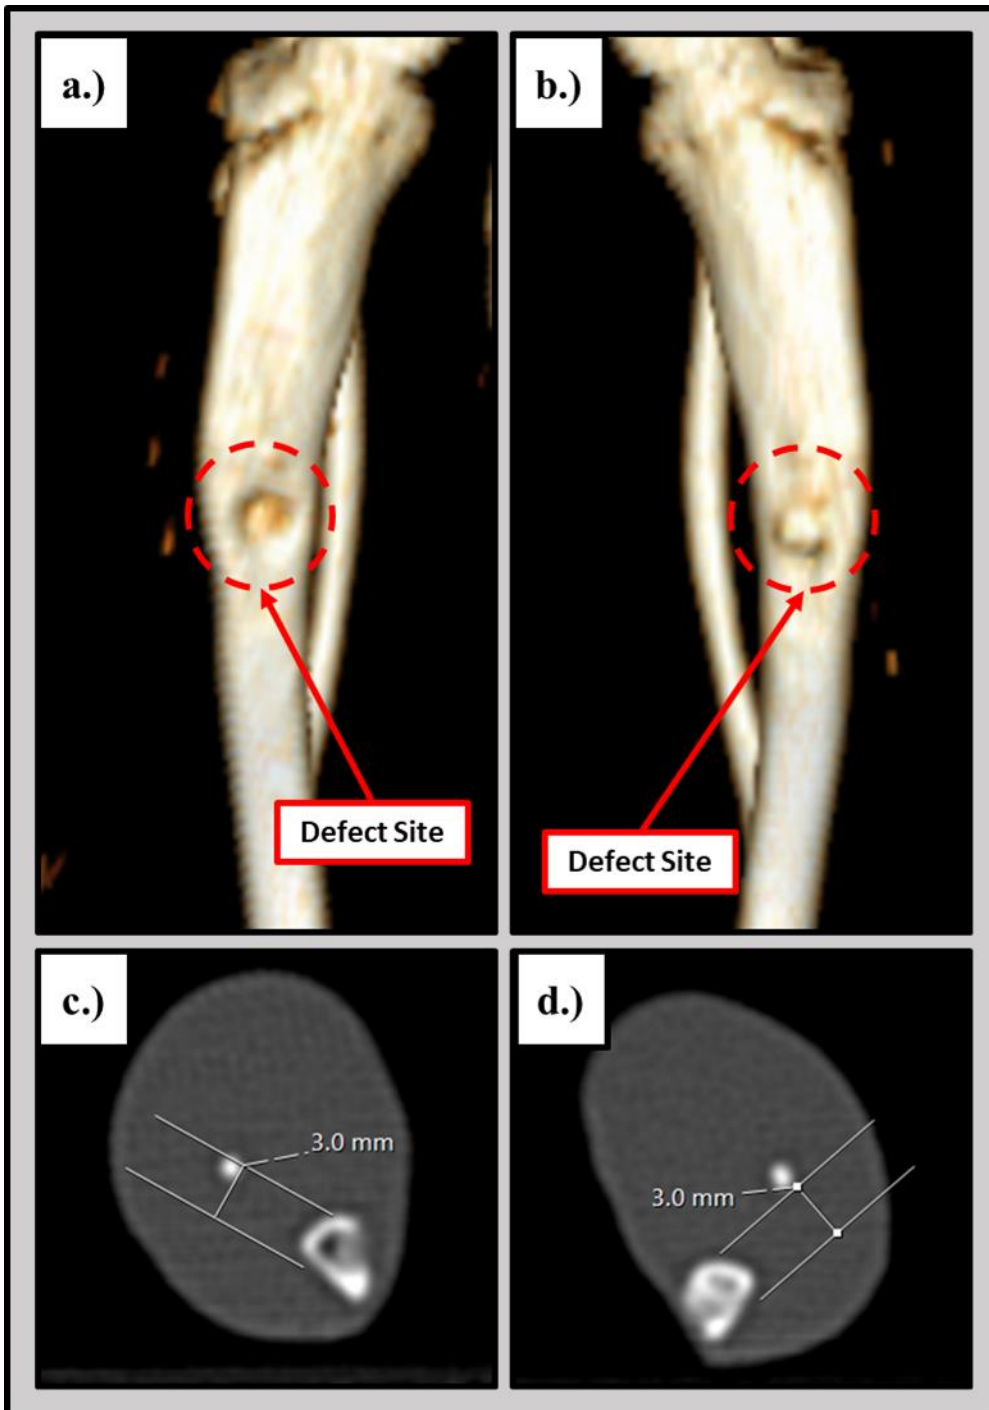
CT 3D renders (a,b) and cross-sectional images (c,d) for expandable design treated tibial defects. Expand-o-graft treated (a,c) and BioOss Collagen® treated defects (b,d) are shown.
